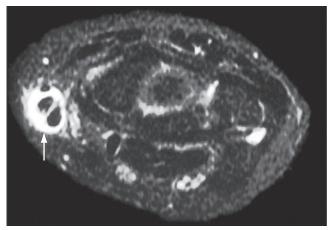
Axial short tau inversion recovery magnetic resonance image demonstrating de Quervain's tenosynovitis. Note the thickened first extensor compartment tendons, with prominent tendon sheath fluid (arrow). (From Edelman RR, Hesselink JR, Zlatkin MB, Crues JV, eds. *Clinical magnetic resonance imaging*. 3rd ed. Philadelphia: Saunders; 2006:3357.)
